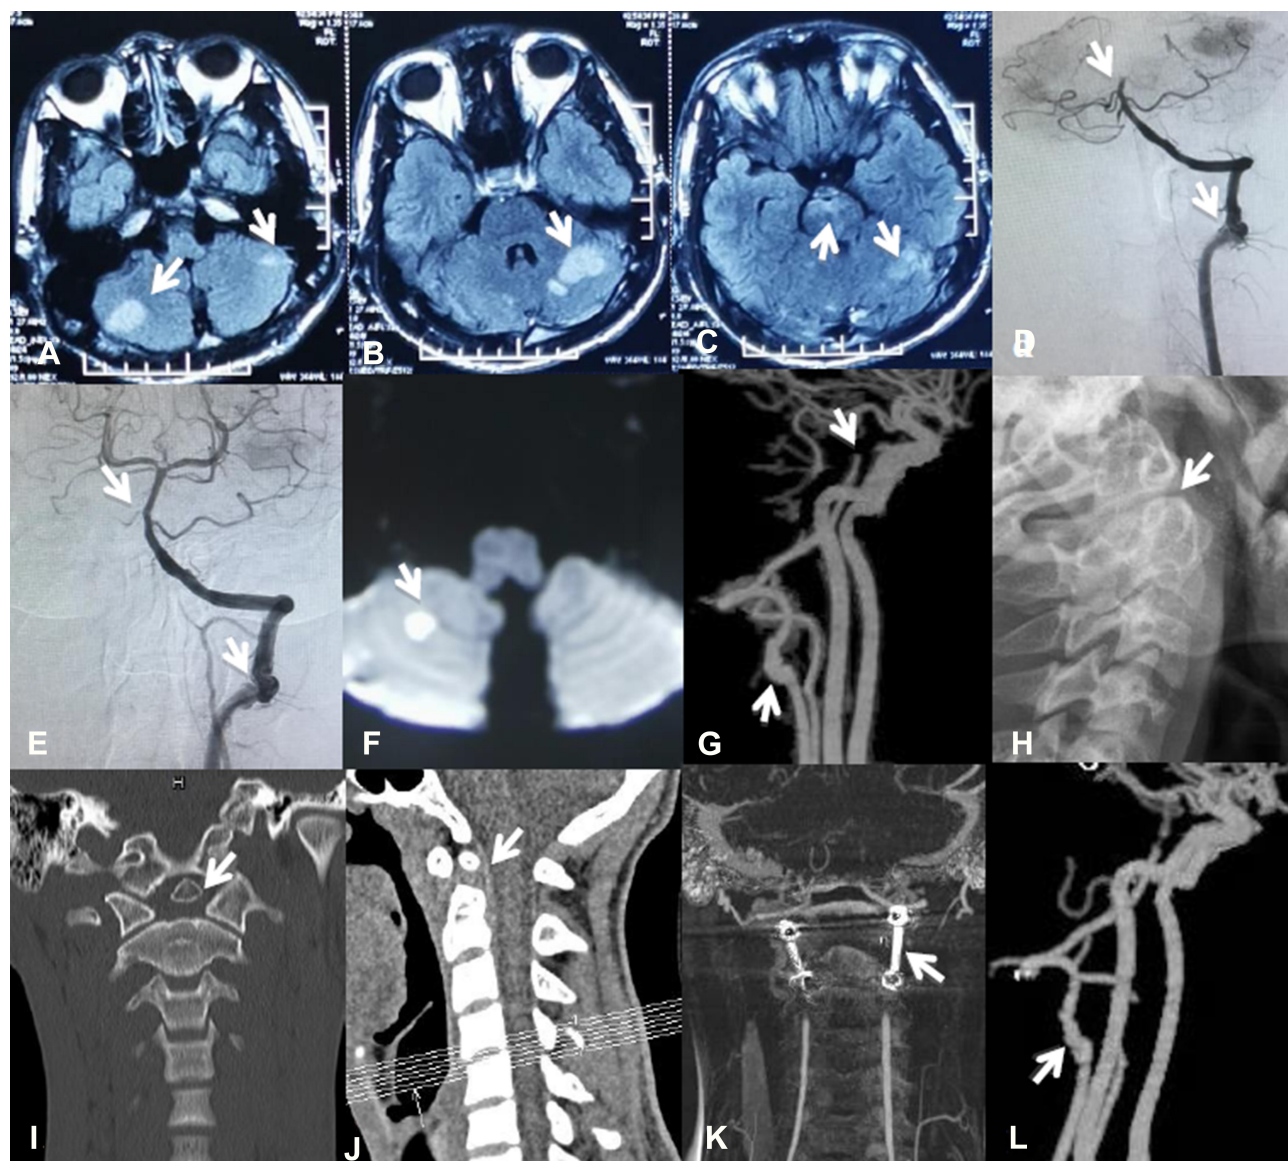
(A–C) Head MRI from a local hospital showing multiple infarcts in the bilateral cerebellar hemisphere and pons (white arrow); (D, E) DSA showing severe distal stenosis or occlusion of the BA, and irregular aneurysmal dilation at the site where the left VA exited the axial foramen and complete recanalization of the BA was achieved after mechanical thrombectomy (white arrow); (F) repeat head MRI showing new infarcts in the right cerebellar hemisphere (white arrow); (G) repeat CTA confirming a dissecting aneurysm in the atlantoaxial segment of the left VA and repeated occlusion of the BA (white arrow); (H–J) cervical vertebra X-ray and 3-D CT both demonstrating os odontoideum (white arrow); (K) CT showing atlantoaxial fusion (white arrow) had been performed on this patient; (L) repeat head CTA 3 months after the surgery revealing dissecting aneurysm on the V3 segment of the right VA had become smaller.
